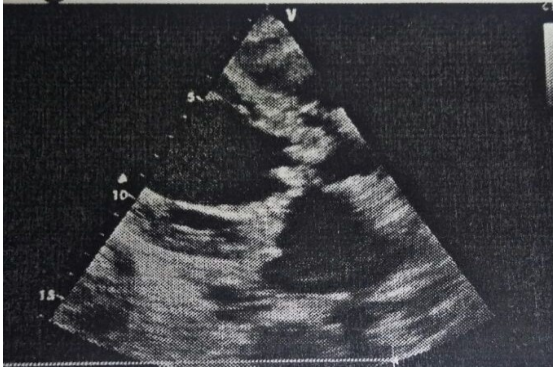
Echocardiogram of the patient.
